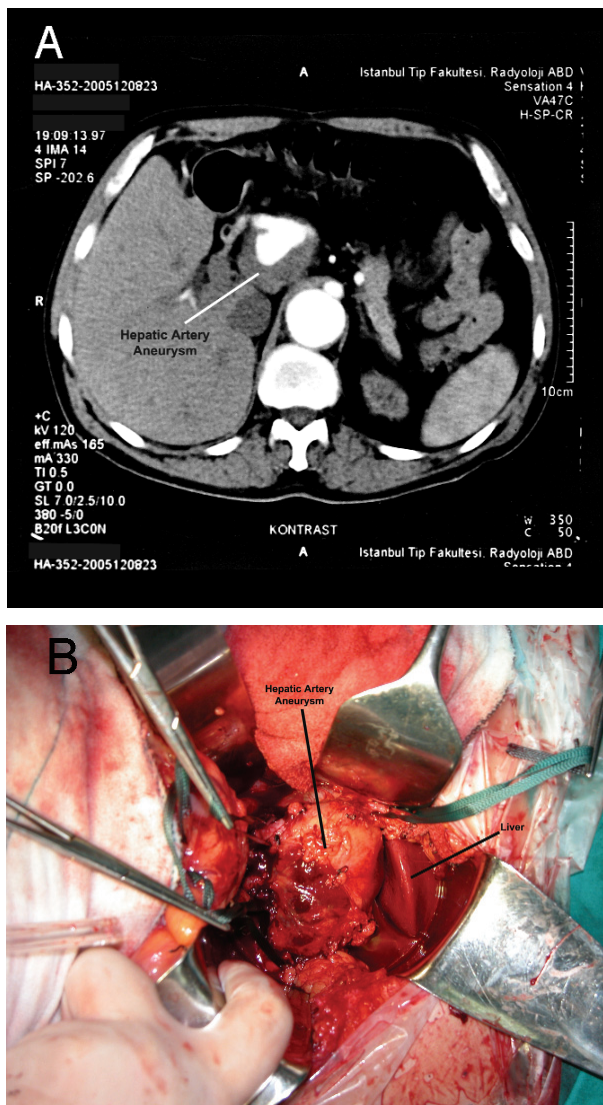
A, Contrast-enhanced computed tomography view of the hepatic artery aneurysm. B, Perioperative photograph of the hepatic artery aneurysm with a size of 3.6 cm.
